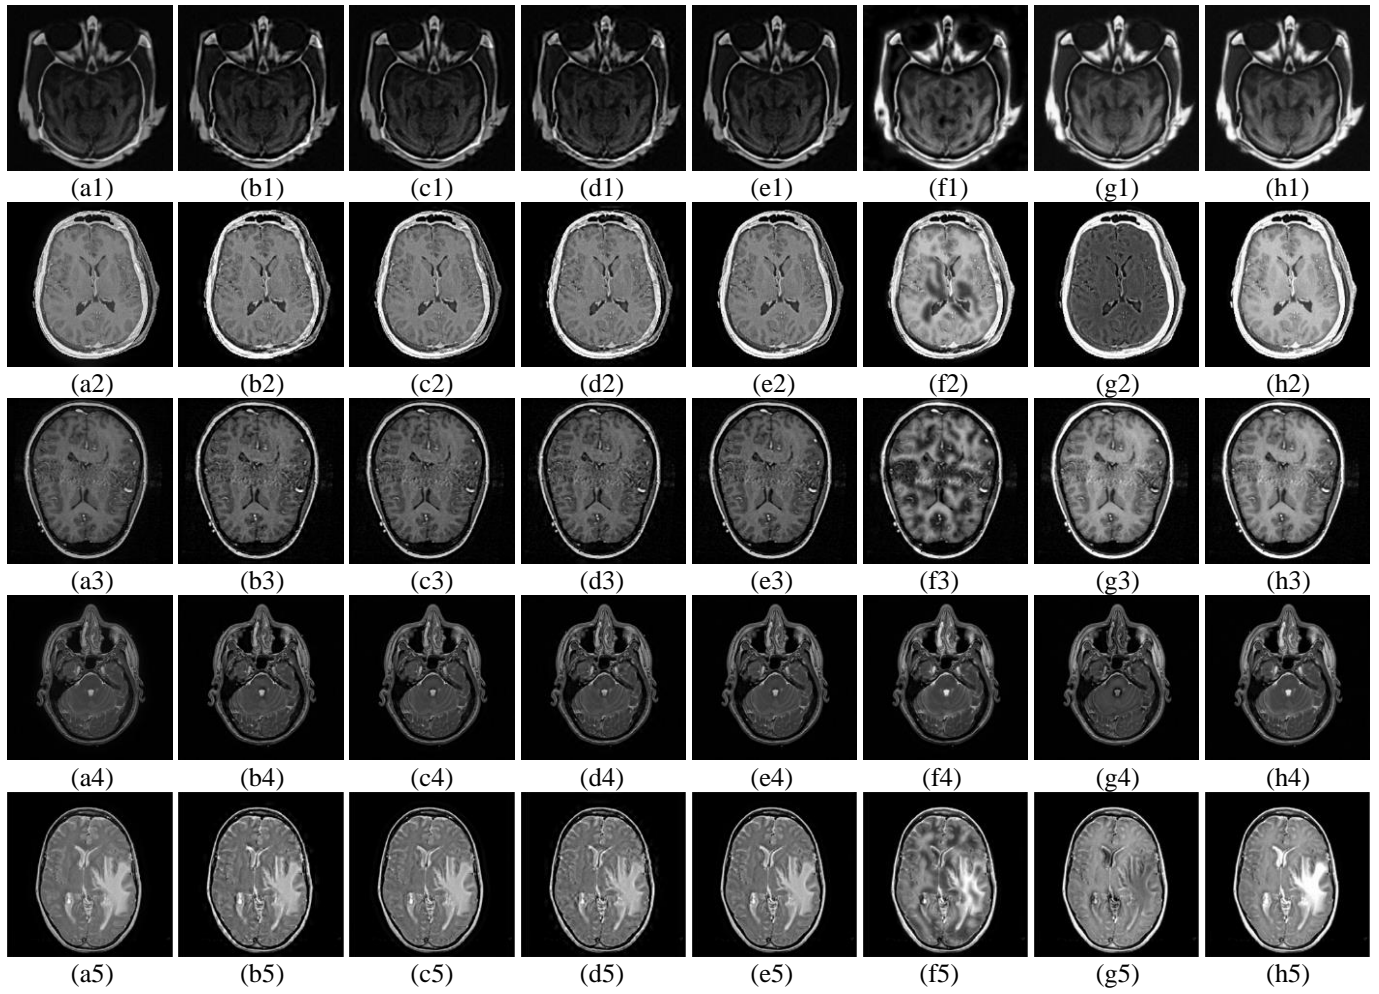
Visual results for the five pairs of CT/MRI images. Fused images from (a1)–(a5) GP based method; (b1)–(b5) DWT based method; (c1)–(c5) DTCWT based method; (d1)–(d5) CT based method; (e1)–(e5) NSCT based method; (f1)–(f5) scheme [22] method; (g1)–(g5) scheme [27] method; (h1)–(h5) proposed method.
